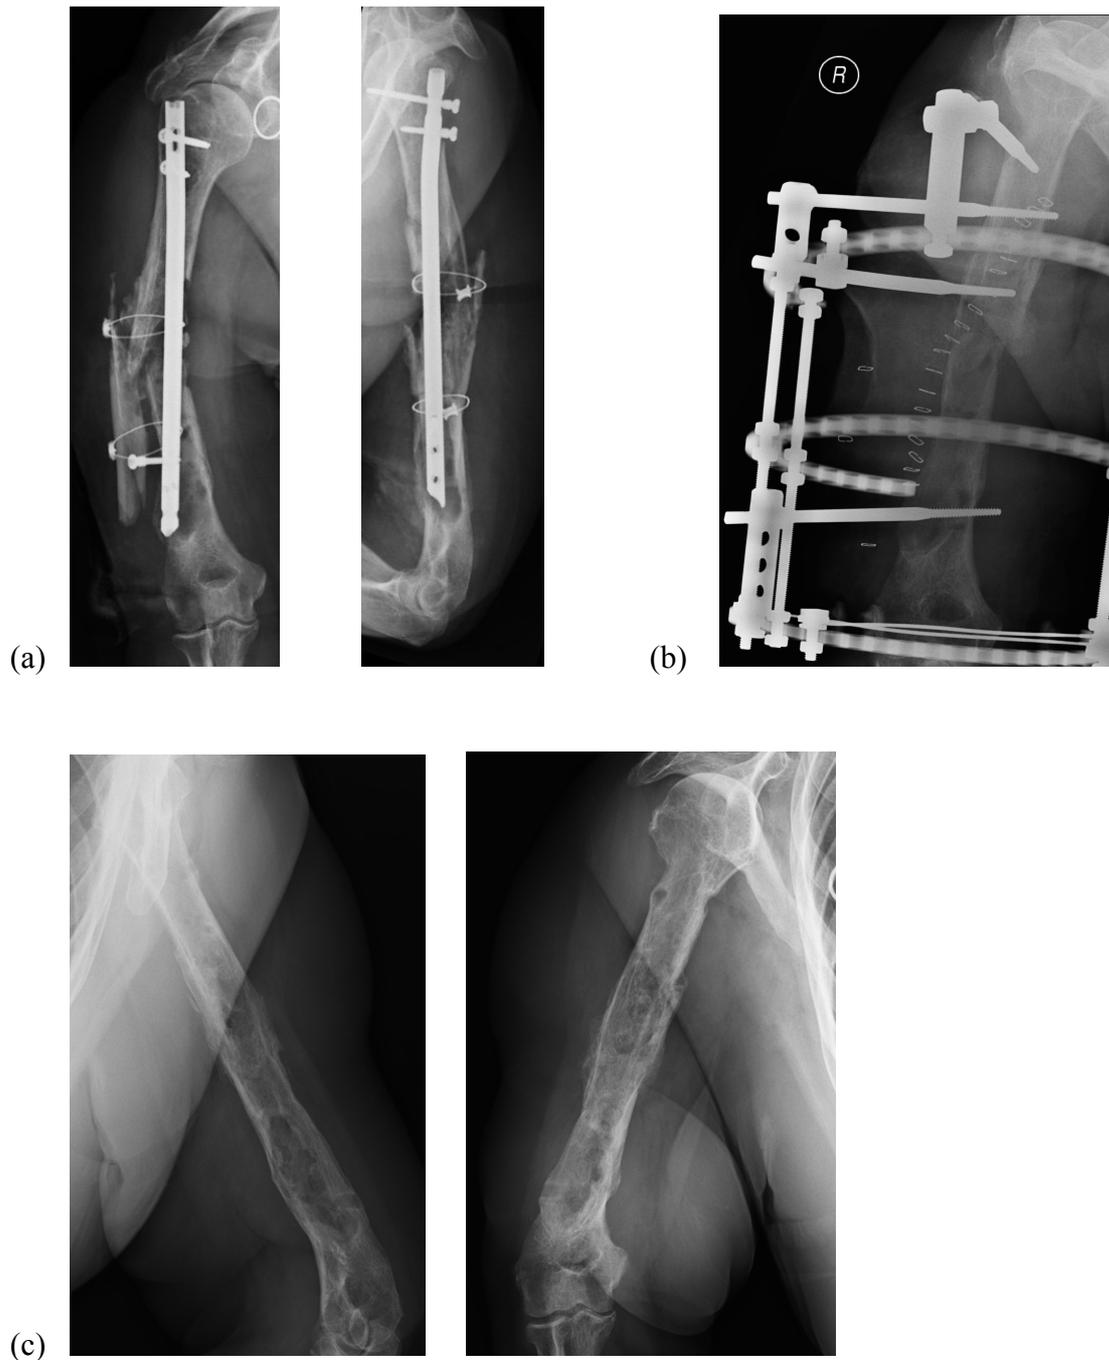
X-ray images of a case involving pre-operative instability (anatomic type IV infection). (a) This 72 year old diabetic patient presented with a septic non-union of the humerus following multiple previous surgeries. (b) Post-debridement reconstruction involved acute shortening, bone graft and circular external fixation. (c) Radiological images following external fixator removal.
